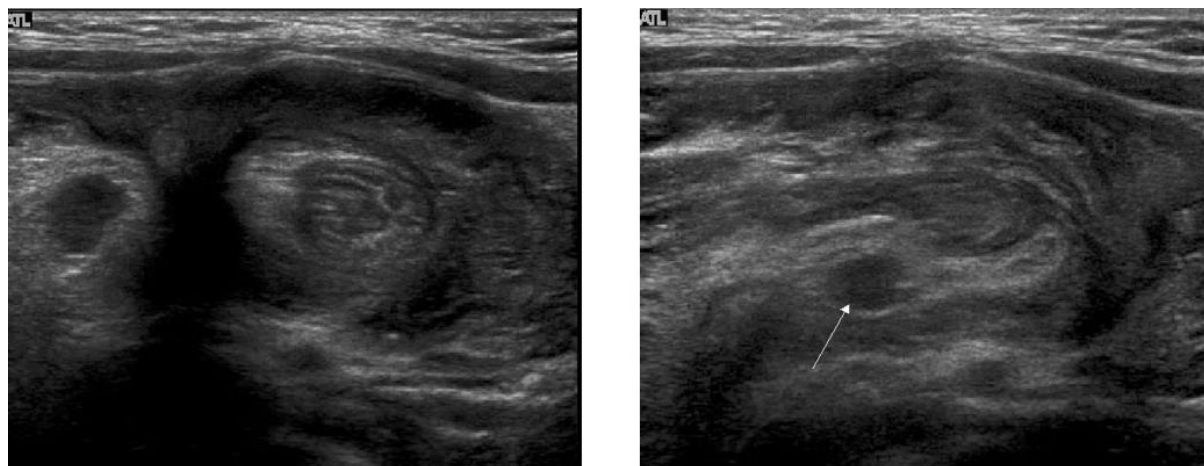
Ultrasonographic images of a 10-month-old boy with cyclic irritability and typical ileocolic intussusception. Transverse (a) and longitudinal (b) US scans show the diameter of the head measuring 2.88 cm and the thickness of the outer rim of the lesion measuring 0.49 cm. There was a mesenteric lymph node (arrow).
